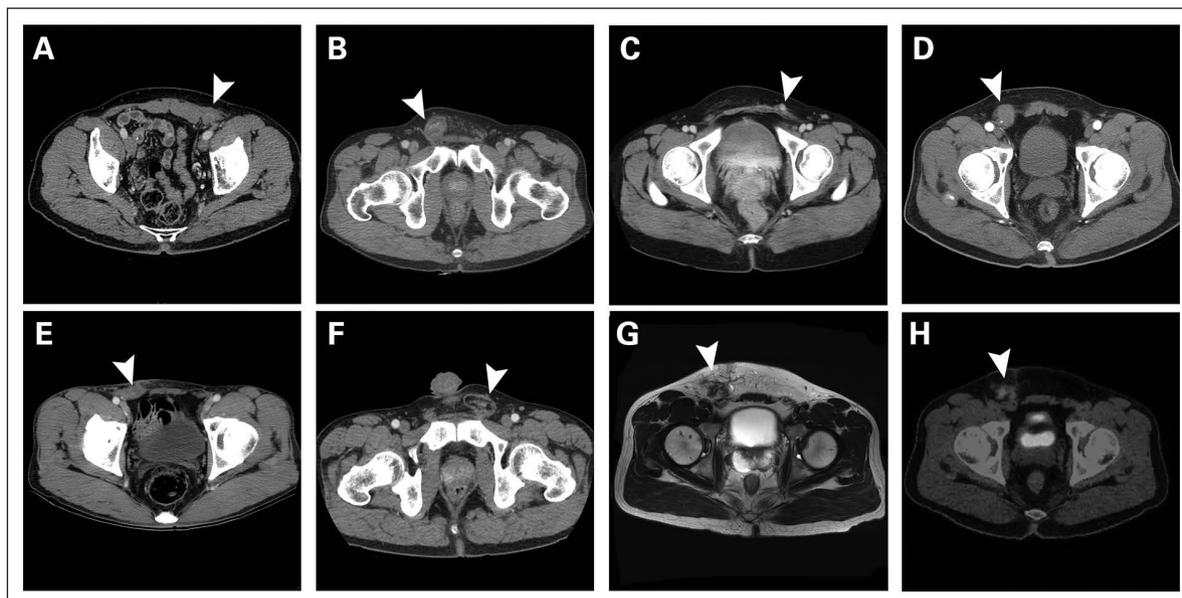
Image findings of patients with inguinoscrotal liposarcoma. A) Patient 7 had a 4.5 cm mass in the inguinal canal. B) Patient 8 had a 4 cm mass in the inguinoscrotal region. C) Patient 9 had recurrence in the left inguinal canal after previous excision of an 8 cm mass. D) Patient 10 had a 12 cm mass in the inguinoscrotal region. E) Patient 11 had a 3 cm mass in the right inguinoscrotal region. F) Patient 12 had a 9 cm mass in the left inguinoscrotal region. Patient 13 had G) a 14 cm mass in the right inguinal canal on magnetic resonance imaging, with H) hypermetabolic features on positron emission tomography. Arrowheads indicate a mass in the inguinal canal.
